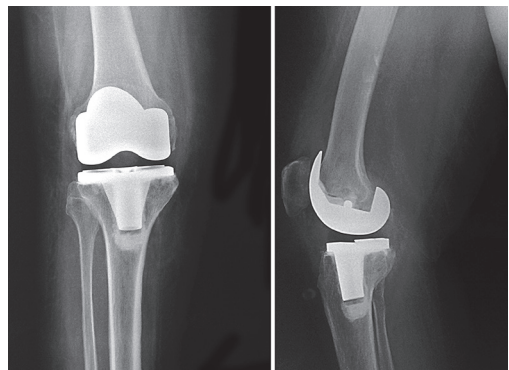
X-ray: Total knee arthroplasty
